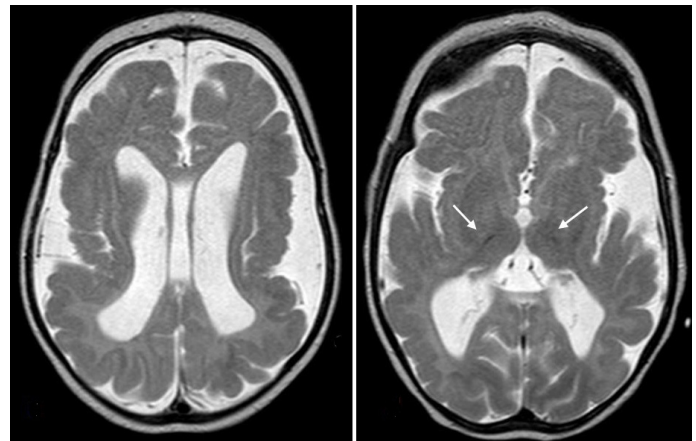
MRI images of a 6-month-old male patient with a homozygous mutation in the *OCNL* gene (pseudo-TORCH syndrome 1). It shows diffuse atrophic volume loss which is more prominent in the cerebral white matter and thalami. Bithalamic calcifications are visible as hypointense foci on axial T2-weighted images (arrows).
